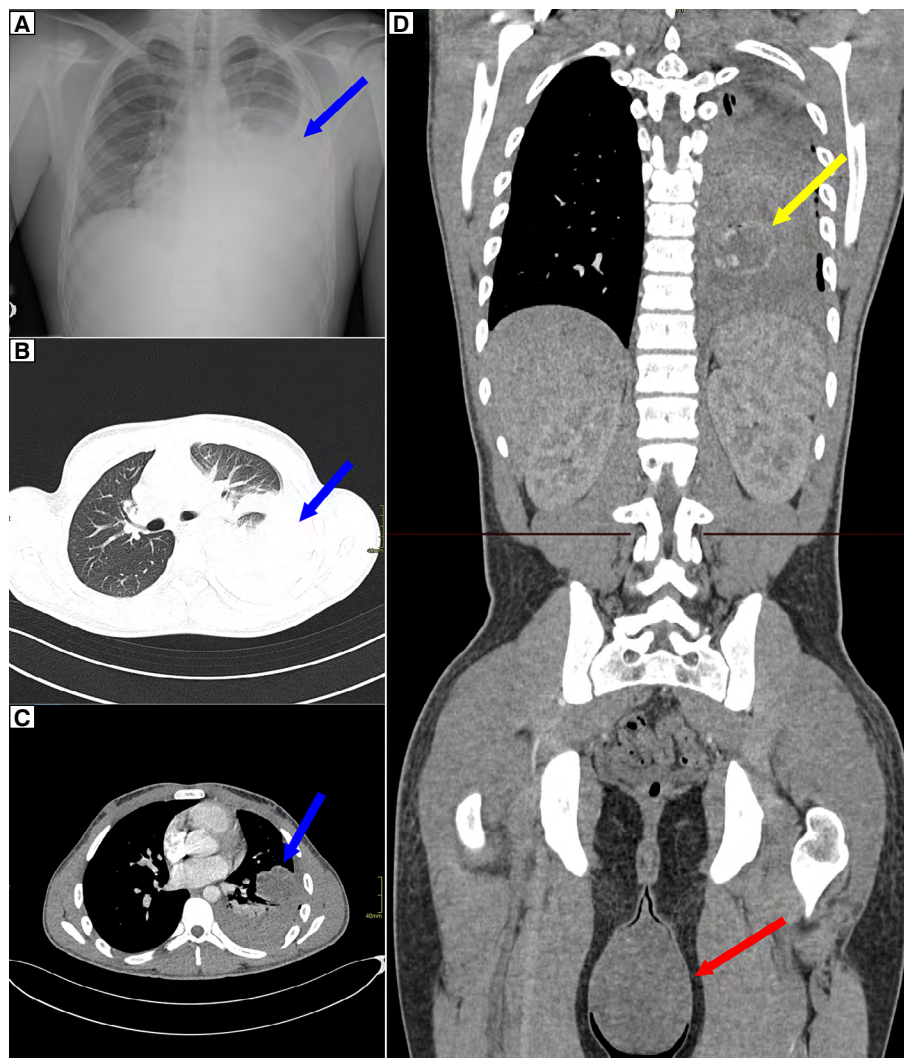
A. chest radiograph, accumulation of fluid in the left lung (blue arrow); B. computed tomography (CT) scan showing atelectatic area and fluid in the left lung (blue arrow); C. CT scan, axial view, reduced atelectasis with persistent fluid and pulmonary metastases (blue arrow) visualized for the first time; D. CT scan, coronal view, pulmonary metastases (yellow arrow) and significantly enlarged left testicle (red arrow)
